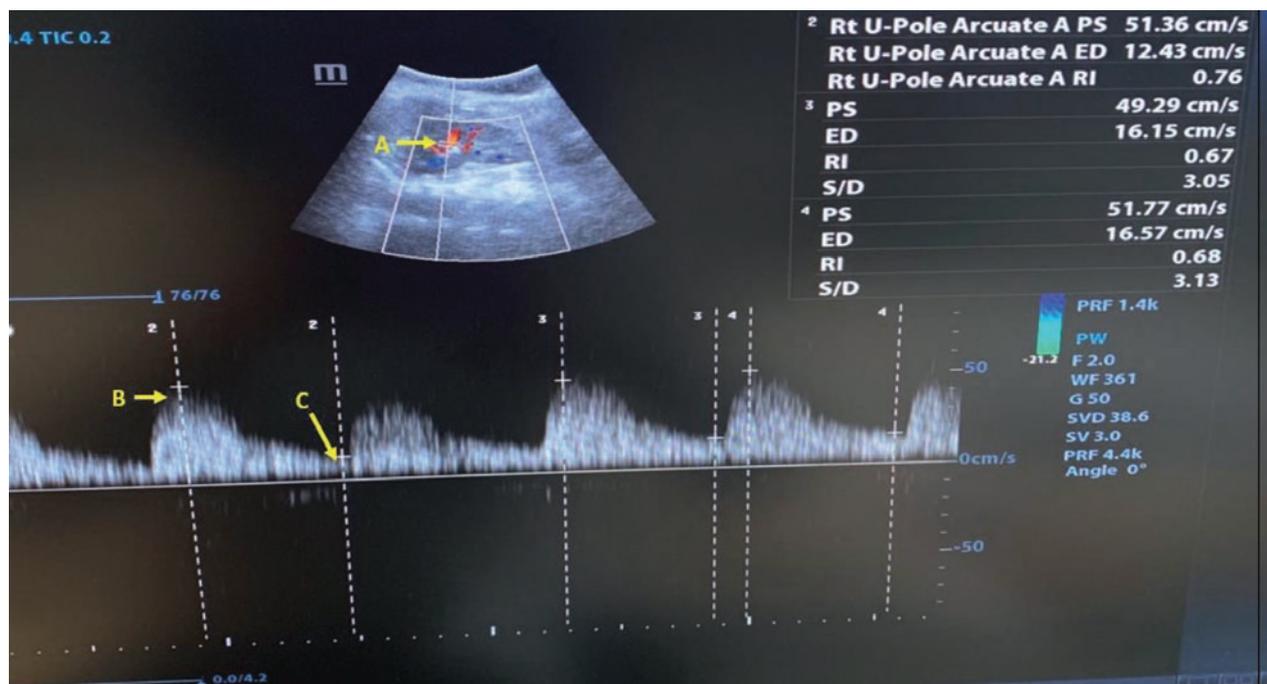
Doppler ultrasonographic assessment of arcuate renal artery. A) Interlober artery; B) Peak systolic velocity; C) End-diastolic velocity
